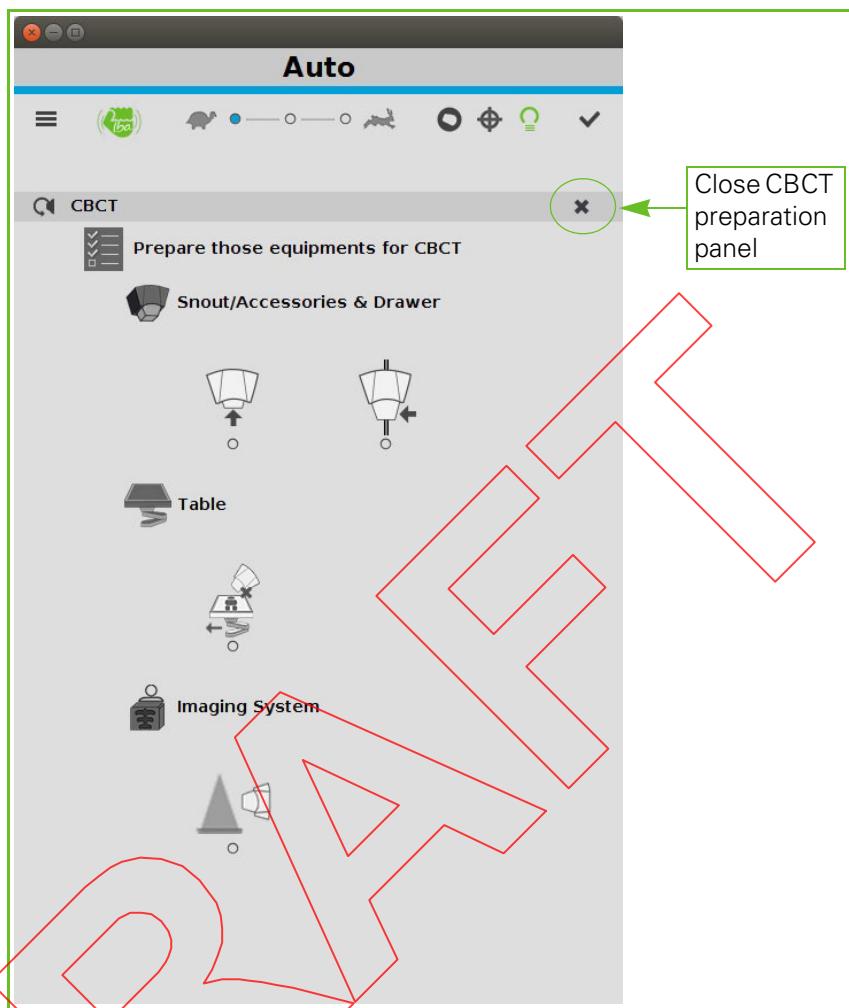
CBCT Preparation Panel (equipment not ready) (typical)
